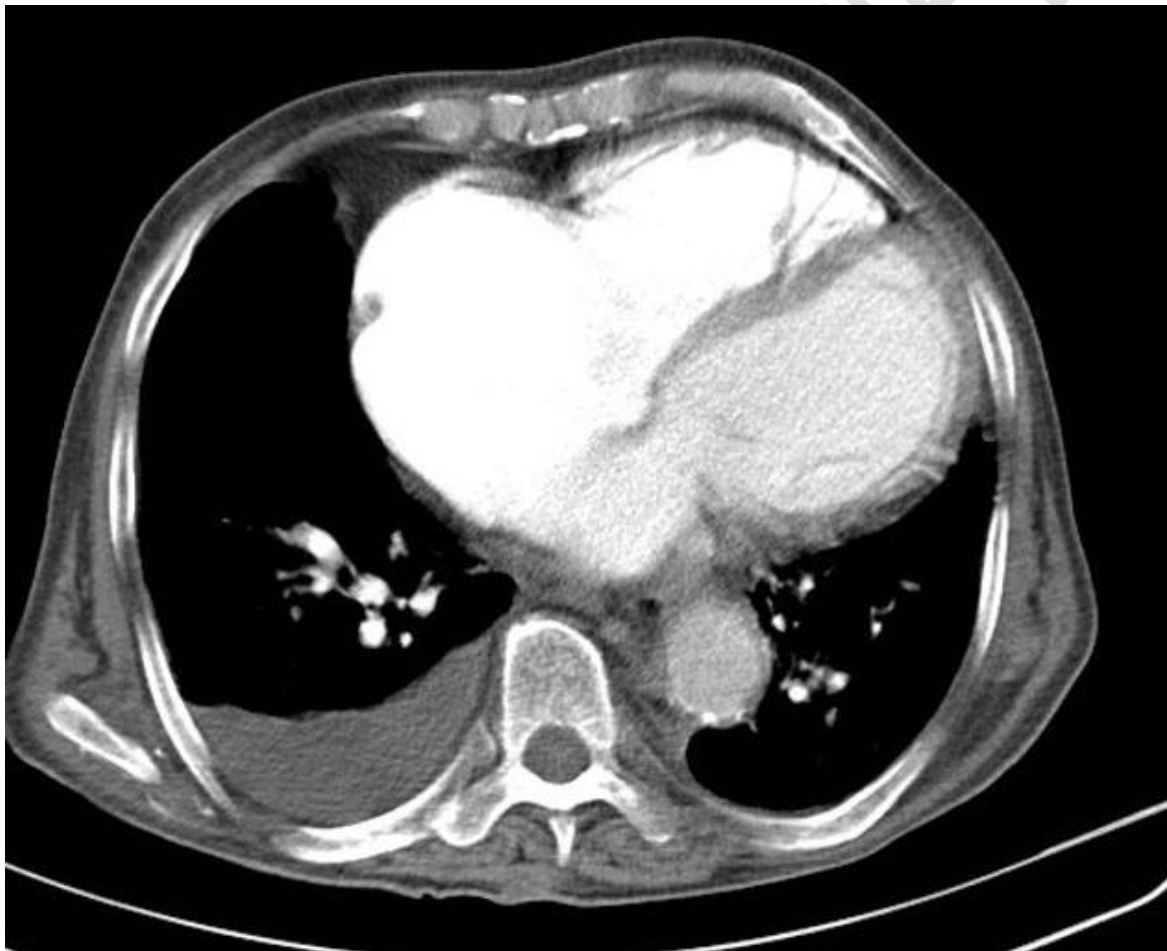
Cardiac computerized tomography (CT) scan for Heart Failure (18)
